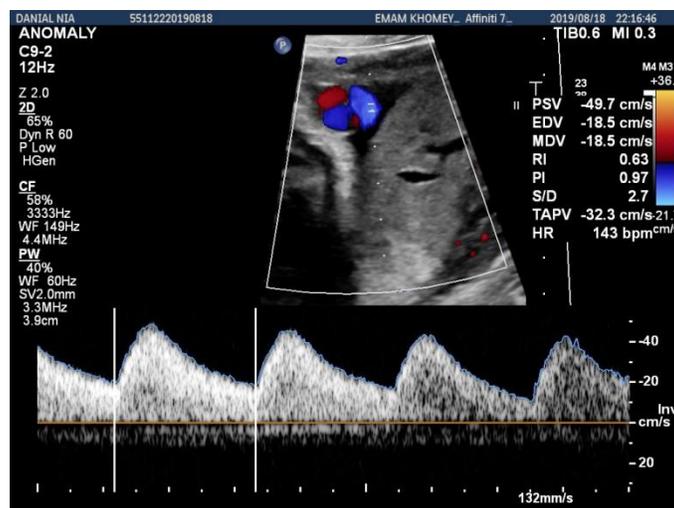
free loop doppler
